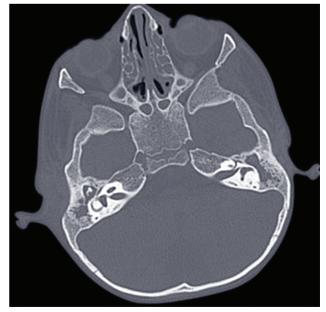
Temporal high-resolution computed tomography showing soft tissue images in the antrum and epitympanum bilaterally.
